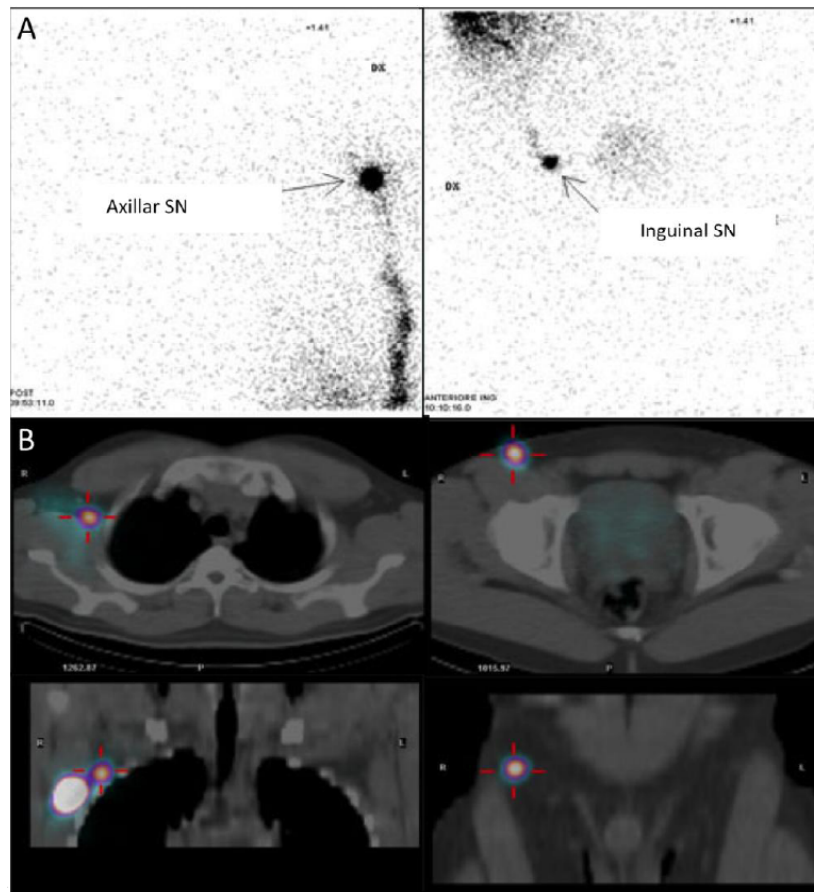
Cutaneous malignant melanoma of the back. Detection of right axillar and inguinal lymph nodes at (A) planar (posterior and anterior views) and (B) SPET/CT (axial and coronal) lymphoscintigraphy.
